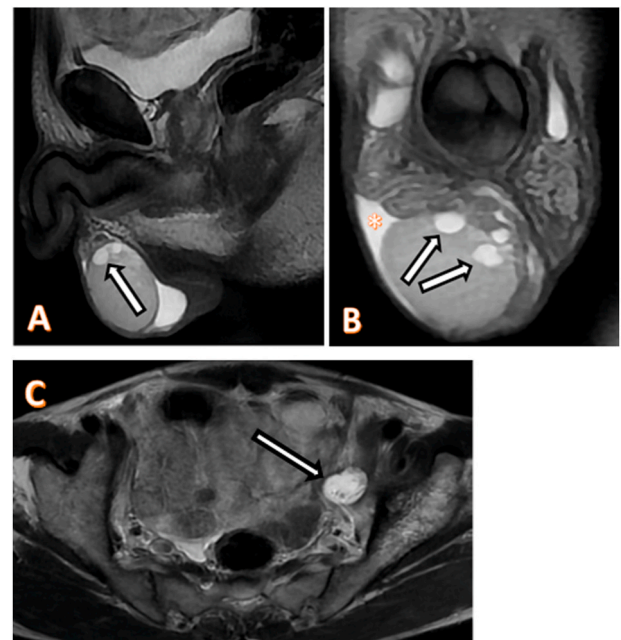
Testicular MRI in T2-weighted Imaging. A: Sagittal section showing a right intra-scrotal testicle with intra-testicular cysts in t2 hypersignal (Arrow) B: Coronal section revealing an empty left hemiscrotum and a normal-sized, regularly contoured right testicle with intra-testicular cysts extending from the testicular mediastinum (arrows) and a low volume hydrocele (asterisk) C: Axial section in T2WI, showing a hypotrophic testicle located in the left iliac region, with heterogeneous signal and a major axis of 2.4 cm.
